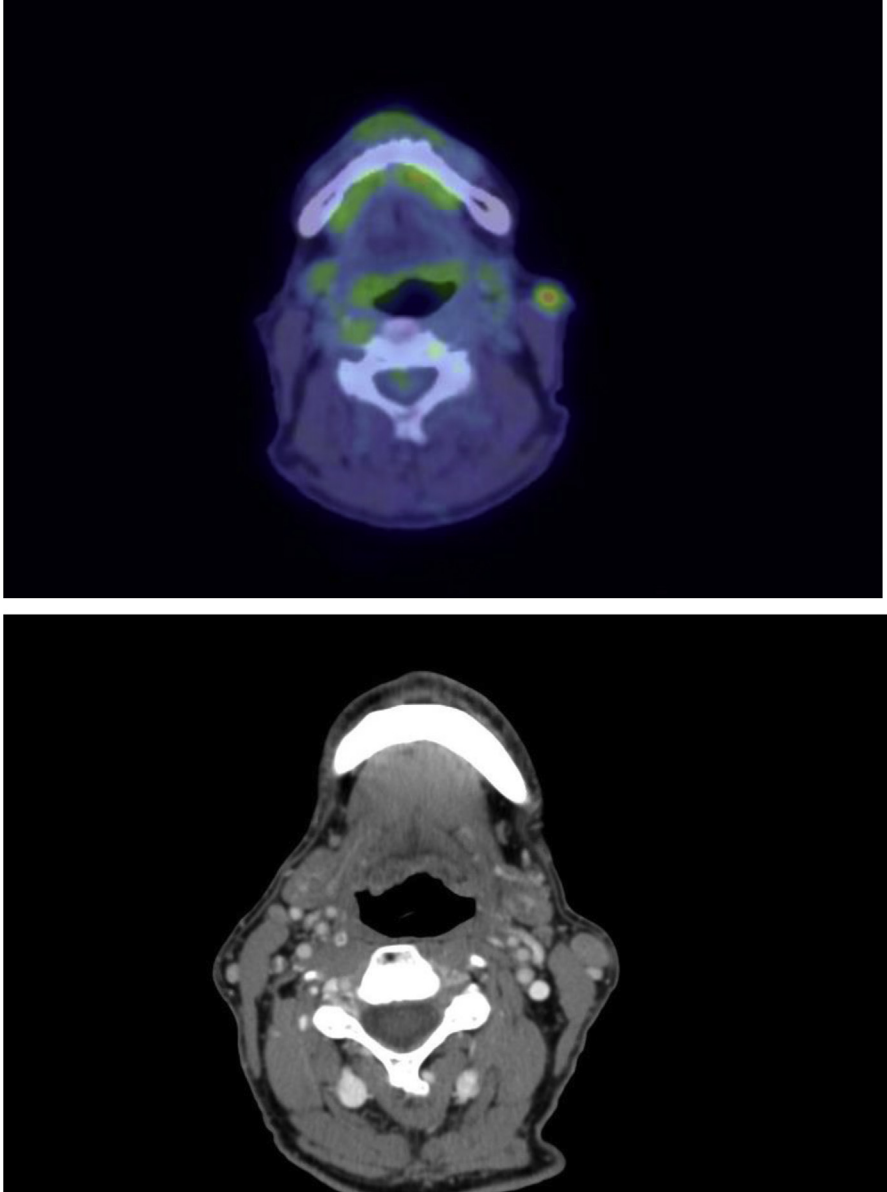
PET-CT (*upper*) and CT with contrast (*lower*) both reveal a single metastatic lymph node within the left external jugular/parotid tail region, in a patient with MCC of UP. Complete skin examination failed to identify the primary tumor source. The patient underwent left parotidectomy with facial nerve preservation and selective neck dissection followed by adjuvant RT. He has no evidence of disease 3 years later.
